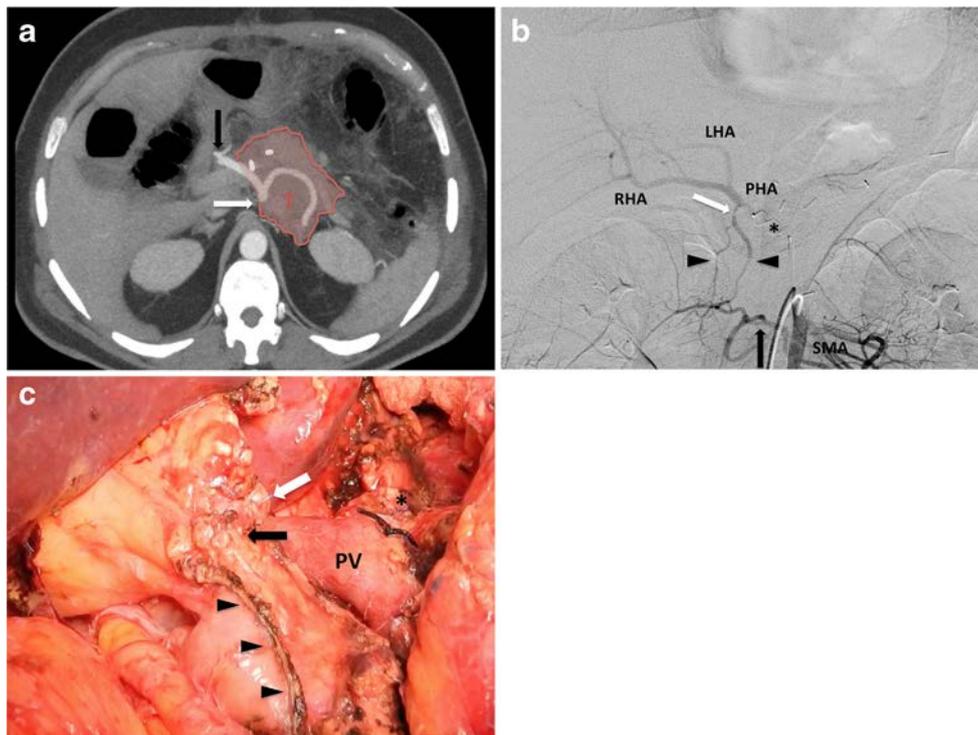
a CT scan in a 42-year-old patient with a pancreatic tumor (*T*) compromising the celiac trunk (*white arrow*) and the origin of the common hepatic artery (*black arrow*). b Preoperative embolization of the common hepatic artery using a vascular plug (Amplatzer type 2–10 mm, *asterisk*). Hepatic perfusion is guaranteed through the pancreaticoduodenal arcades (*arrow heads*) between the gastroduodenal artery (*white arrow*) and the inferior pancreaticoduodenal arteries (*black arrow*). Distal perfusion of the proper hepatic artery (*PHA*), right hepatic artery (*RHA*) and left hepatic artery (*LHA*) is evidenced after injecting
